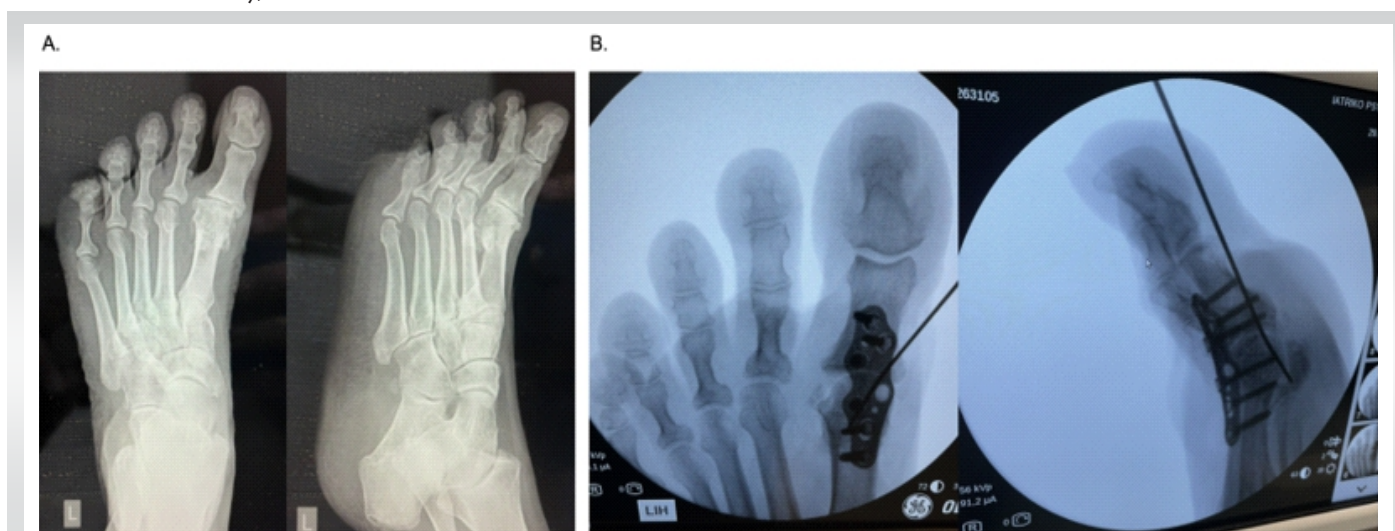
Pre-operative weight-bearing anteroposterior and lateral radiographs demonstrating advanced hallux rigidus with hallux varus deformity and associated second- and third-toe deformity. Intraoperative fluoroscopy following primary first metatarsophalangeal arthrodesis performed using cup-and-cone preparation and low-profile dorsal plate fixation.
